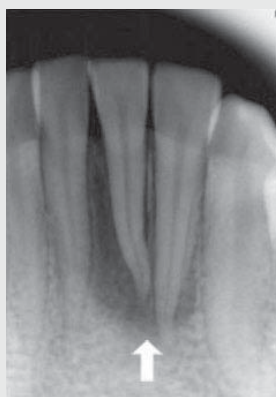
Periapical x-ray showed periradicular radiolucency around mandibular incisors
